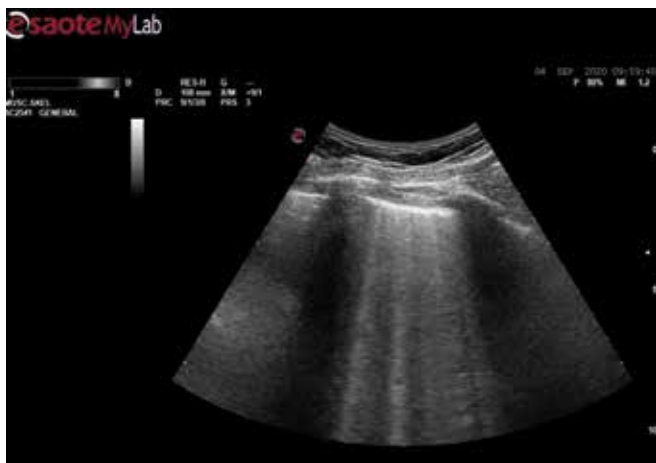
Lung ultrasound shows multiple B-lines
